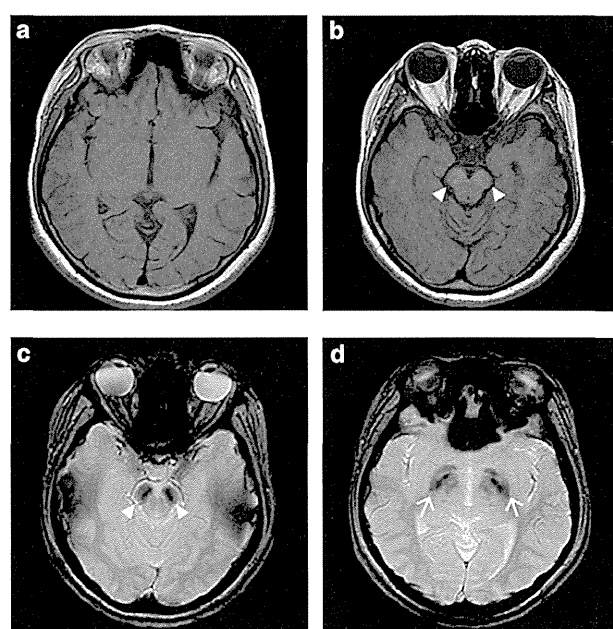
Brain magnetic resonance imaging (MRI) of the patient at 14 years of age. T1-weighted (a, b), and T2*-weighted (c, d) axial images of the patient at 14 years and 6 months of age. T1-weighted images show normal findings in the globus pallidus (a), but hyperintensity of the substantia nigra with a weak central band of T1WI hypointensity (b, arrowhead). T2*-weighted images show strong hypointensity in the substantia nigra (c, arrowhead) and the globus pallidus (d, arrow).
